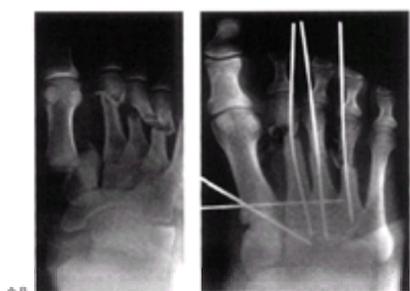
Tarsometatarsal displacement. A: Anteroposterior projection of the foot of a 14-year-old boy who sustained a plantar flexion injury in a motor vehicle crash. There is complete dislocation of the first metatarsal-cuneiform joint and medial displacement. There are fractures of the second, third, and fourth metatarsal shafts. The ipsilateral tibial fracture was treated with intramedullary fixation. The swelling in the foot was attributed to the tibial shaft injury, and diagnosis of the foot injury was delayed. B: The postoperative anteroposterior radiograph demonstrates reduction and pinning of the fracture-dislocation.
